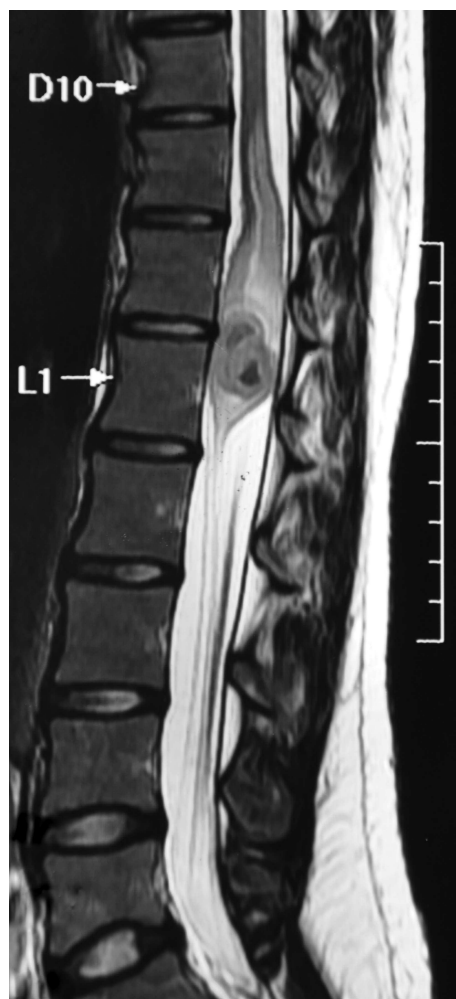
Magnetic resonance imaging of the lumbosacral region revealed an intramedullary lesion of heterogeneous signal intensity on T2-weighted images at the level of conus medullaris with cord expansion and edema.
